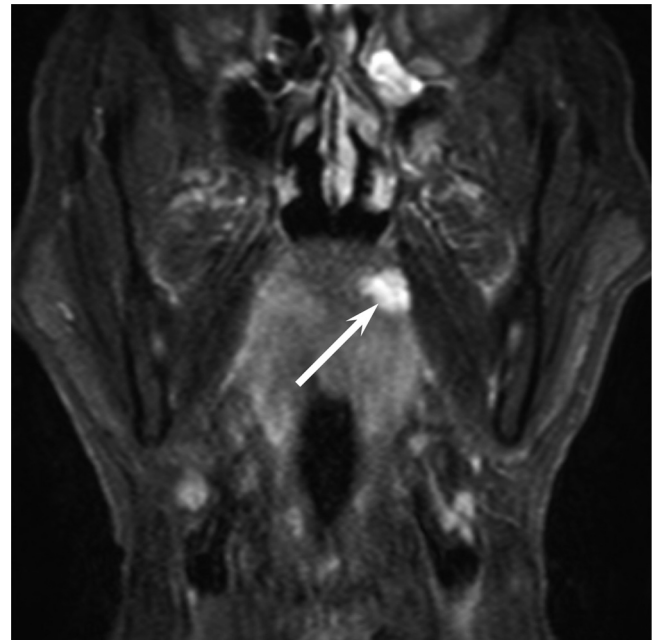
A 37-year-old man with myoepithelioma of the right soft palate. Coronal fat-suppressed T2-weighted images shows a heterogeneously hyperintense lesion (arrow) with internal hypointense areas (arrow head).
